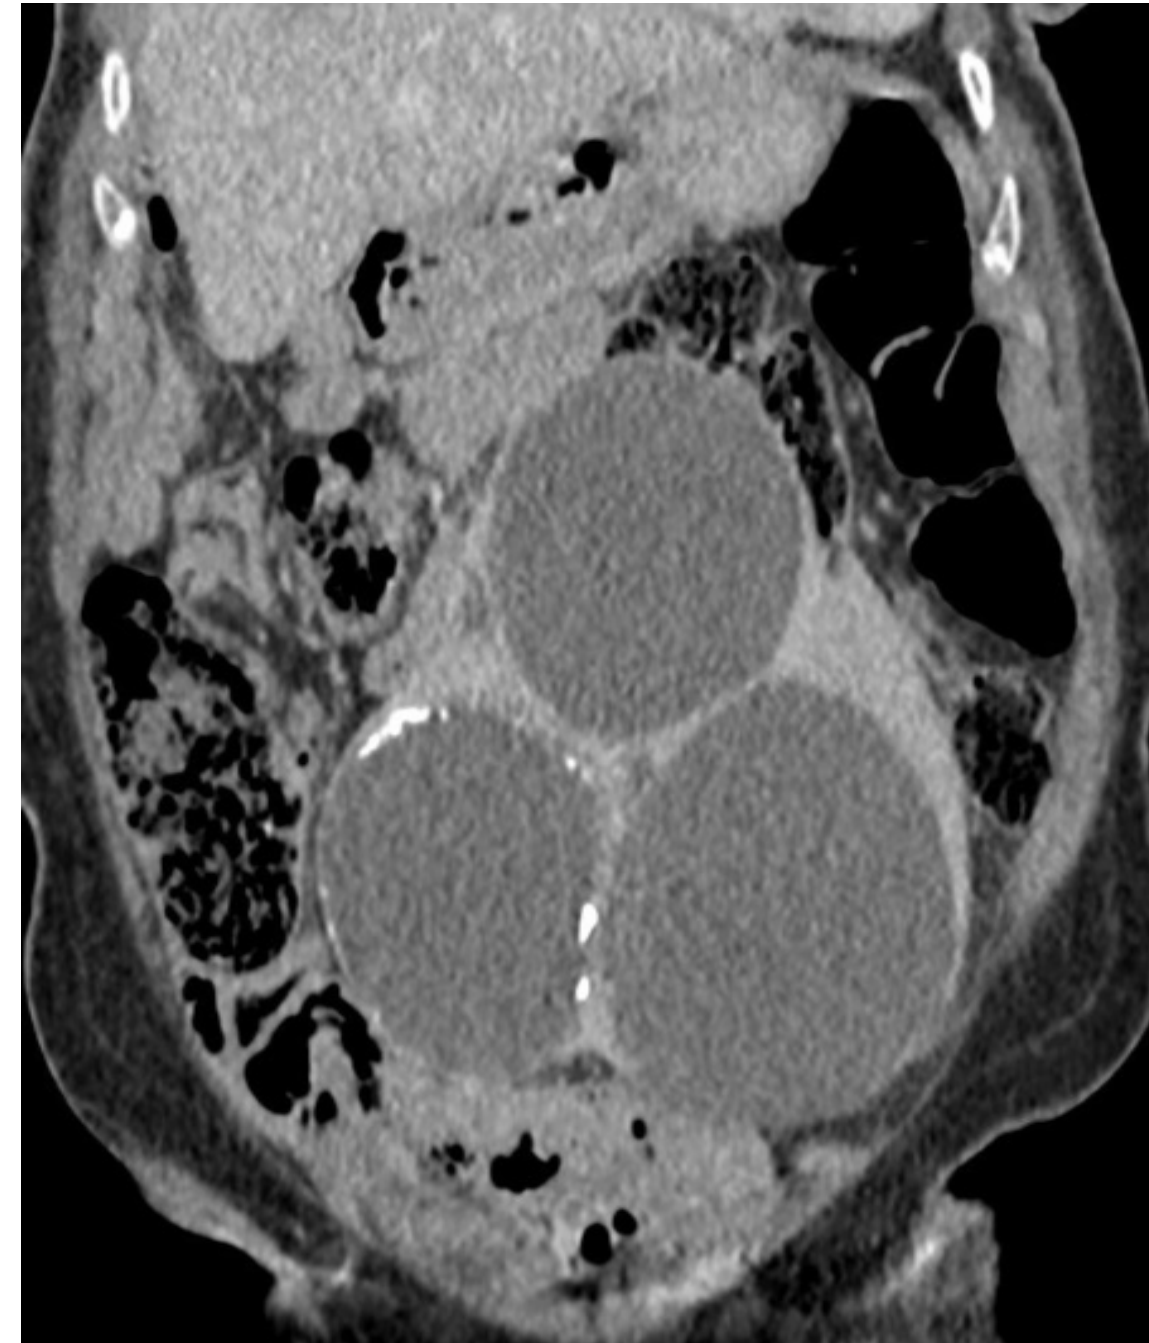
Staging CT performed 2 weeks later showing change in cyst configuration
